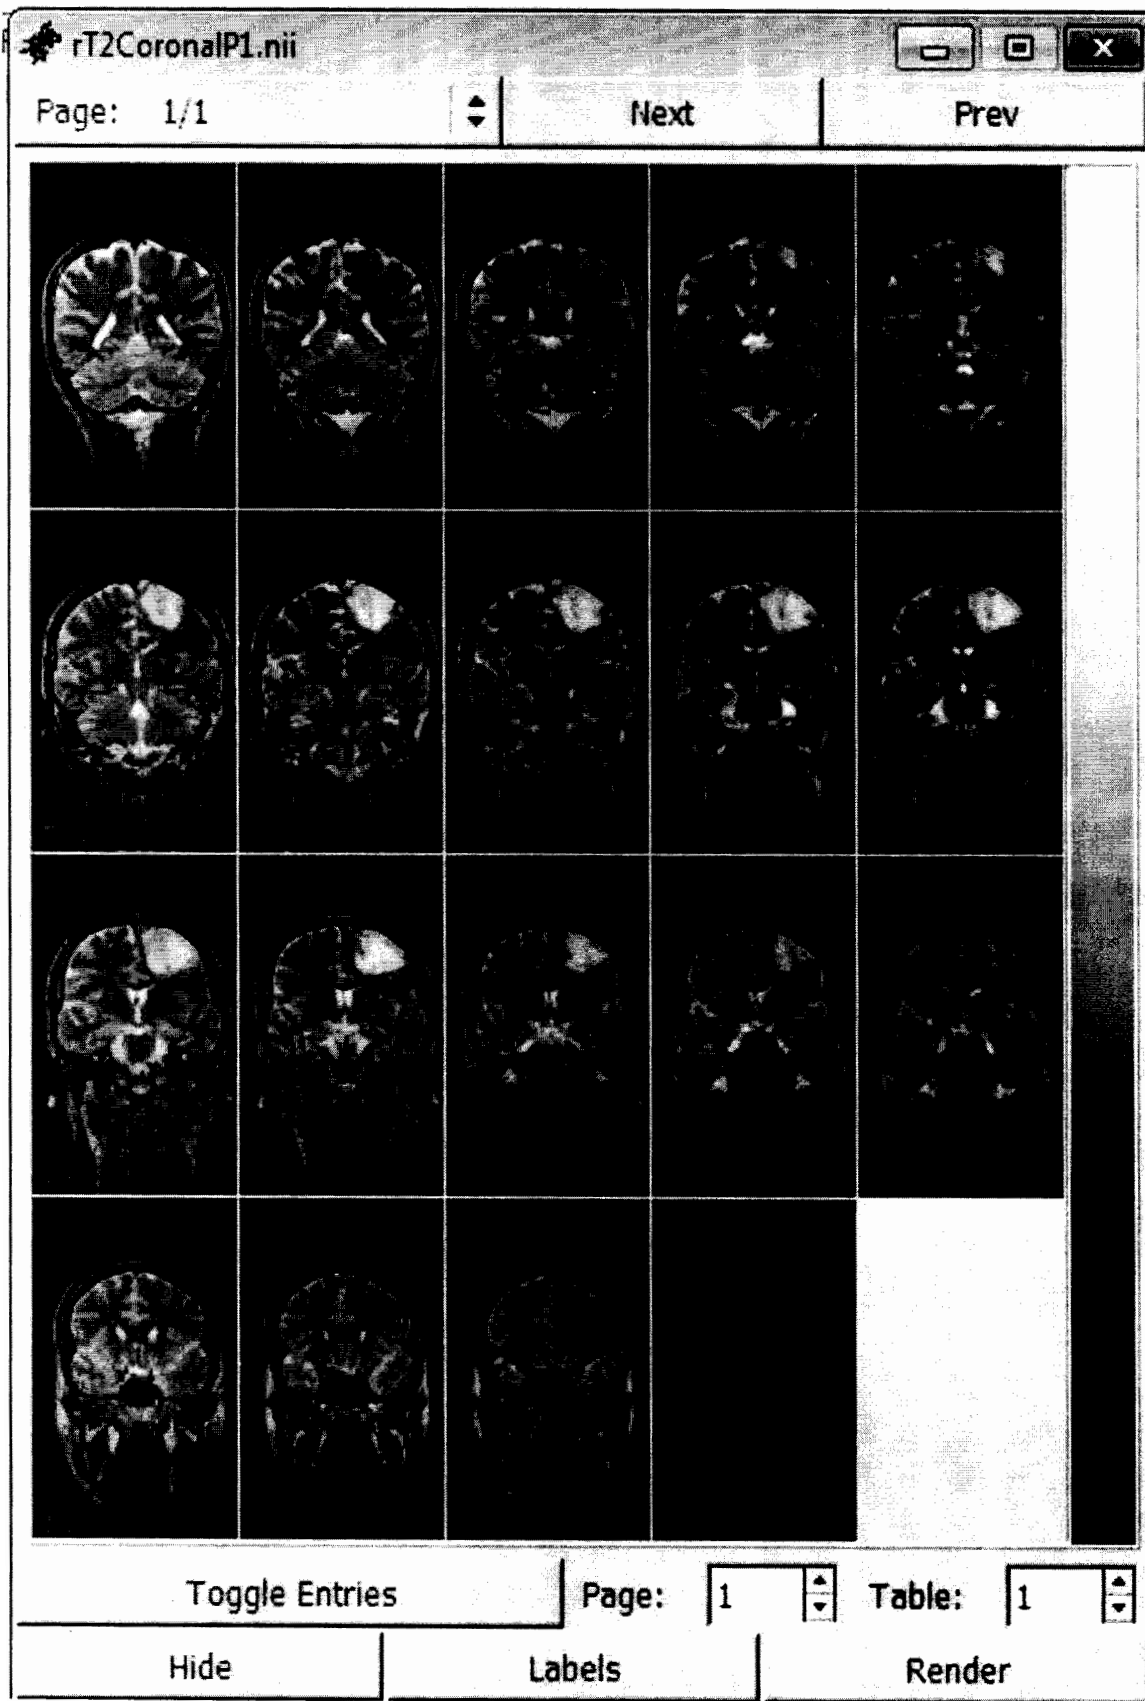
is the complete set of acquired images in greater details from magnetic resonance imaging machine. The images are sliced in three planes namely axial, coronal and sagittal. Figure 4.2 (a) is the 2-D axial plane images. Figure 4.2 (b) is the 2-D coronal plane images and Figure 4.2 (c) is the sagittal plane images. The contrast of the images can be increased after adding contrast agent which adds more details and makes easier for the radiologists and doctors to detect tumor and its roots. Moreover, images can also be modified as per requirement of the medical experts. All images are of different angles which help in detection and finding out exact location of the tumor inside the skull.
